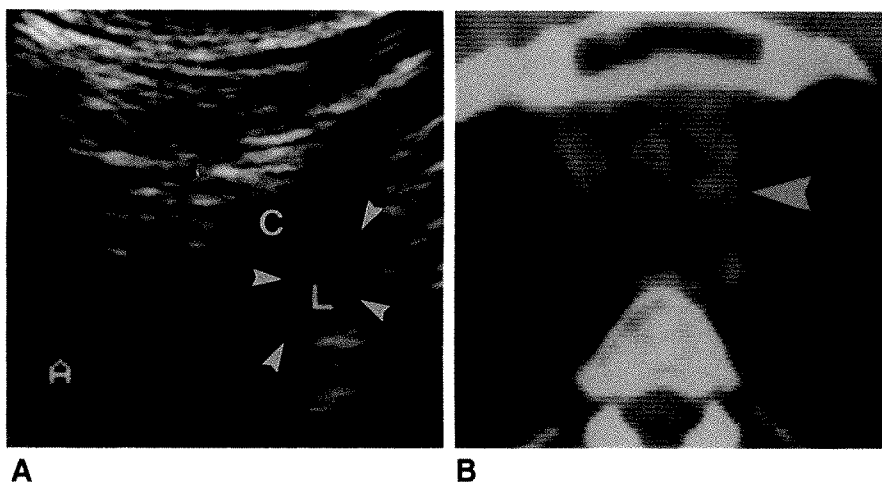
Sonogram and CT scan in 30-year-old man with recurrent lymphoma.
